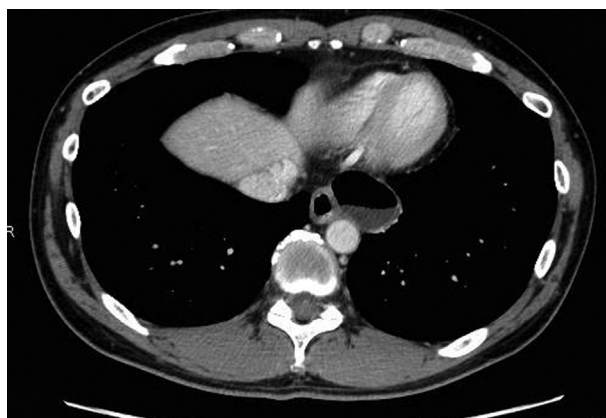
Preoperative CT scan view. The epiphrenic diverticulum was located on the left side of the esophagus and behind the heart, with no extrinsic compression. The maximum diameter was 40 mm.
